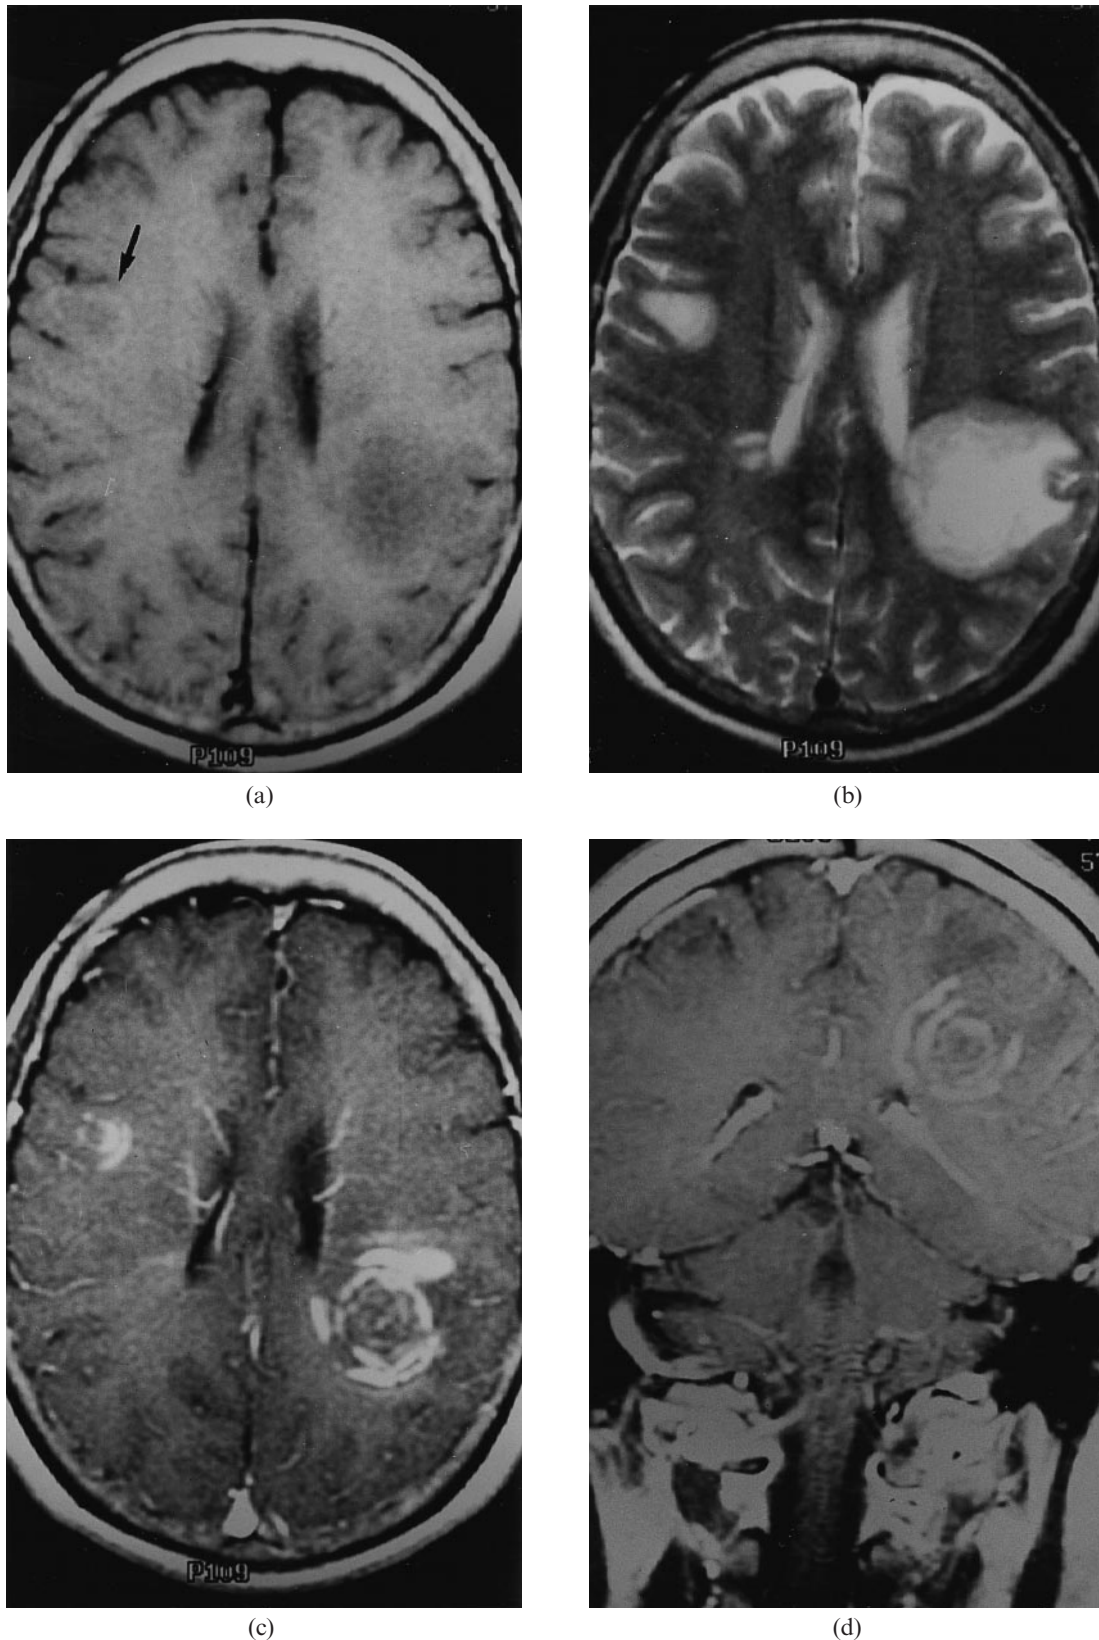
MRI 17 days after the onset of symptoms. (a) Axial T_1 weighted image and (b) T_2 weighted image shows nodular lesions in the left parietal and right frontal subcortical region (arrow). Two small plaques were also noted in the right periventricular region. (c) After contrast enhancement, axial T_1 weighted image shows enhancement of concentric rings in the left frontoparietal lesions, laminated arcuate enhancement of the right frontal subcortical lesion, and dot enhancement of the right periventricular lesions. (d) The striking concentric enhancement of the left parietal lesion is also seen on the coronal contrast enhanced T_1 weighted image.
